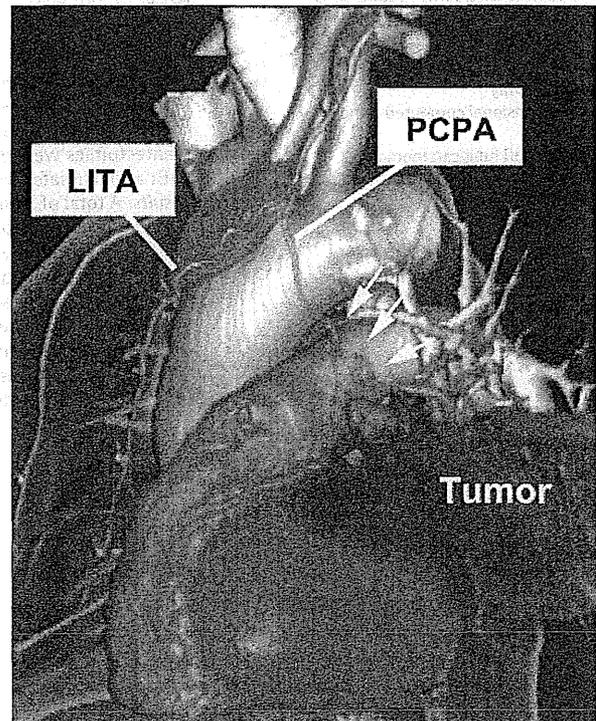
Three-dimensional computed tomography angiography showed that the blood supply to the lesion was continuing from a pericardiophrenic artery (PCPA), which was a branch of the left internal thoracic artery (LITA), not from the lung or the chest wall.
